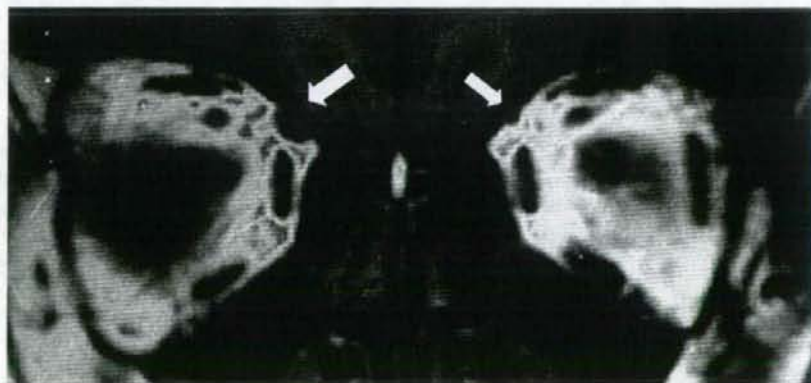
Coronal magnetic resonance imaging scan of a 4-year-old boy with class III tendon anomaly (Case 1) showing a marked hypoplasia of the left superior oblique muscle. The larger white arrow points to the right superior oblique tendon and the smaller white arrow points to the left superior oblique tendon.
